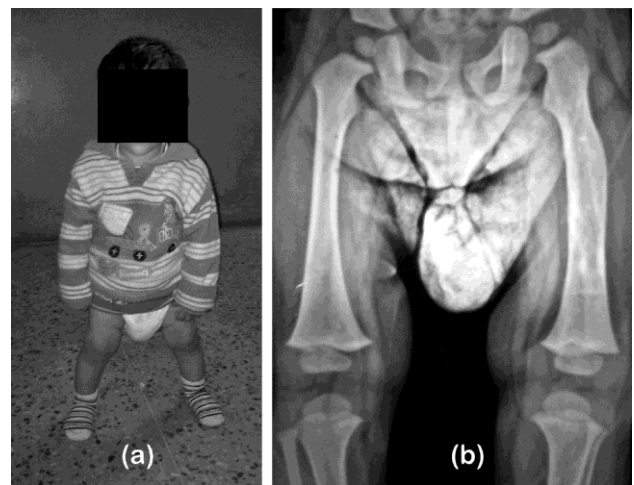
Final followup after 15 months. a) Normal weight bearing with no limb length discrepancy or deformity. b) Radiograph of both femur showing nearly re-sorbed sequestrum and near complete remodelling of left femur leaving no trace of the disease.
